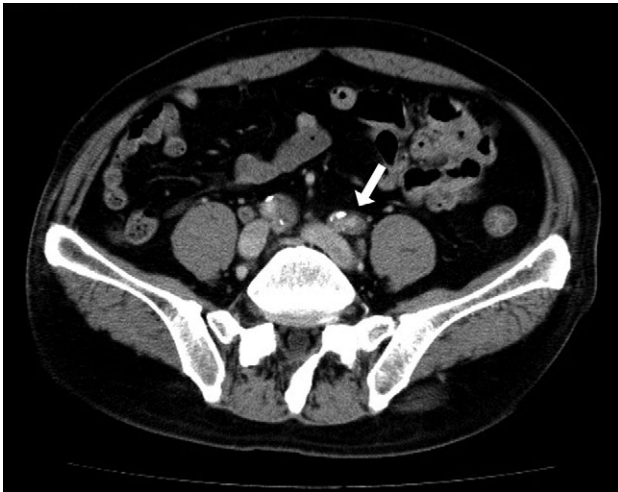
Preoperative abdominal CT showed bilateral iliac arterial stenosis to 5 mm diameter with calcification (the arrows). Internal iliac arteries had been obstructed bilaterally.
